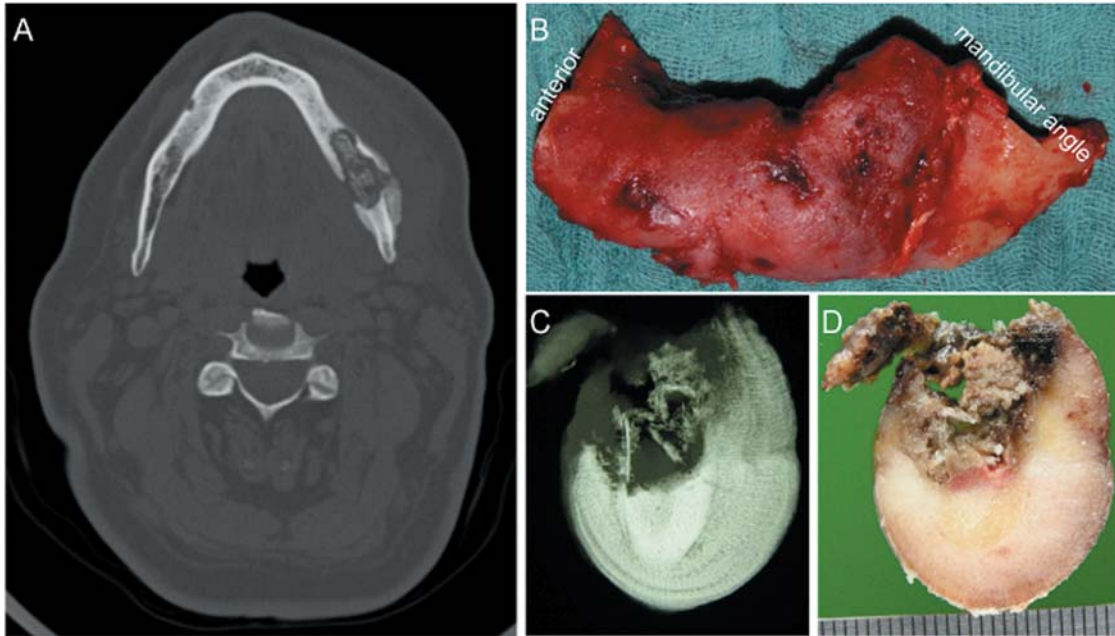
BRONJ, gross findings. (A) Clinical CT showed an osteolytic jaw bone lesion with central sequester. (B) The surface of the jaw bone was covered with new periosteal bone formation. (C) Slab radiograph revealed a central sequester, and the remainings of cortical bone with concentric lamellated new periosteal bone formations. (D) Macroscopically, brownish necrotic tissues were apparent.
